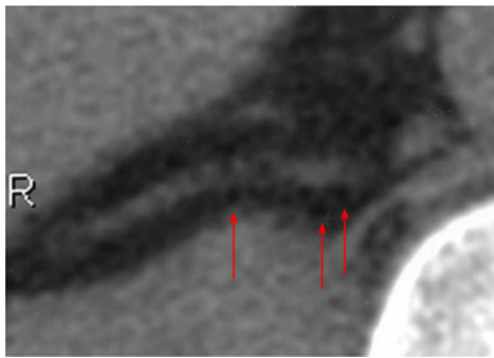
Patient with CNC and PPNAD. Unenhanced CT image (slice thickness of 3 mm) of the right adrenal shows multiple, small, round hypodense areas (red arrows) corresponding to pigmented nodules
